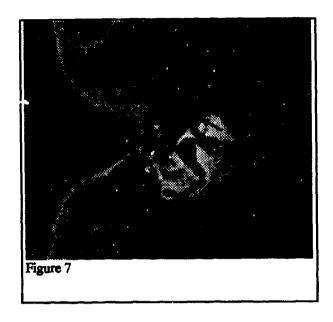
Corresponding CT slice. This is the data from which the 3d models were generated. The black arrow points at the geniculate ganglion.
